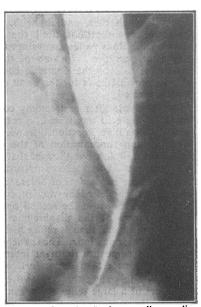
Case 2. Barium-swallow radiograph seven months after partial gastrectomy, showing simple stricture of lower end of oesophagus, with considerable dilatation above the narrowed segment.
